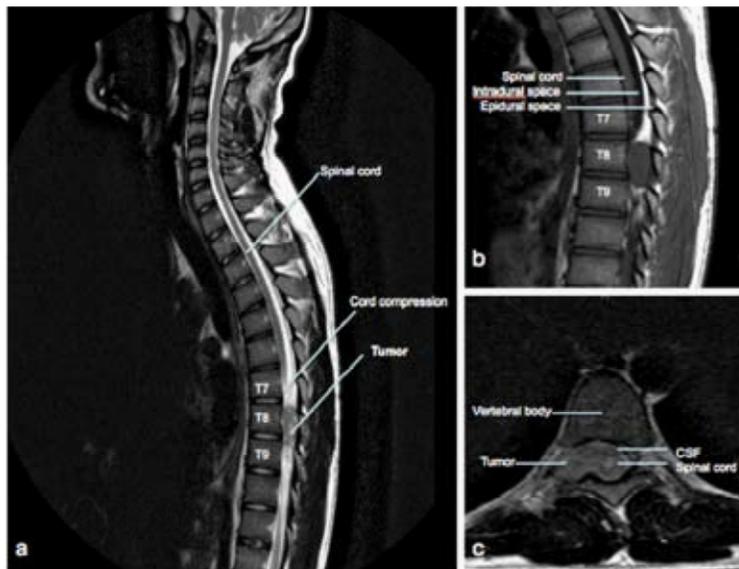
MRI Spine: a. T1 longitudinal view; b. T2 longitudinal view; c. T1 transverse view
